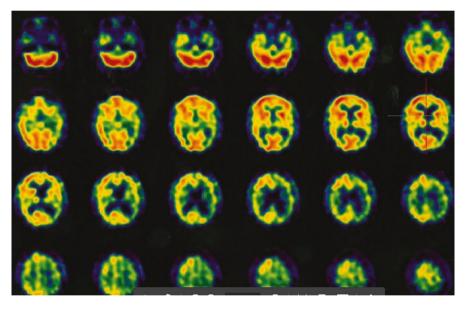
Cerebral SPECT, axial view, showing a heterogeneous pattern of hypoperfusion in the left cerebral hemisphere
